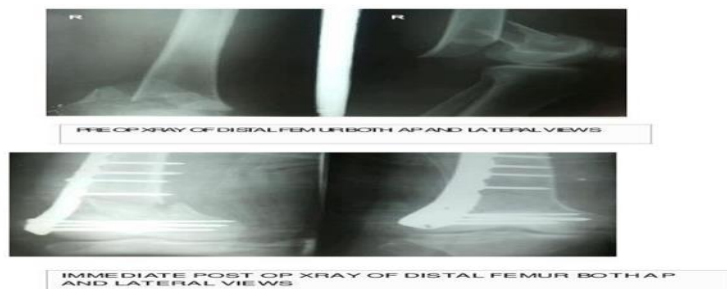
Pre-op Xrays of distal femur AP and Lateral views; Immediate post-op X ray
